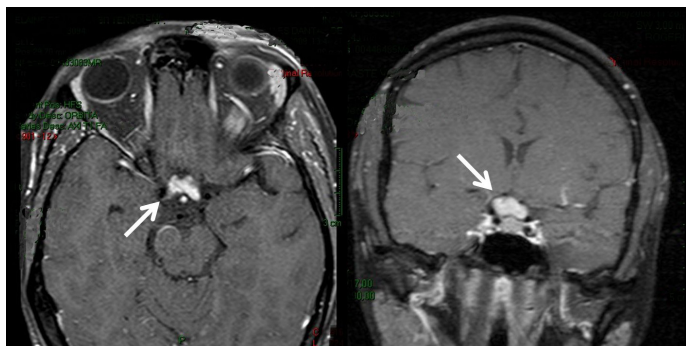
Axial (A) and coronal (B) contrast enhanced T1-weighted MRI sequences showing an optochiasmatic tuberculoma (white arrows).
